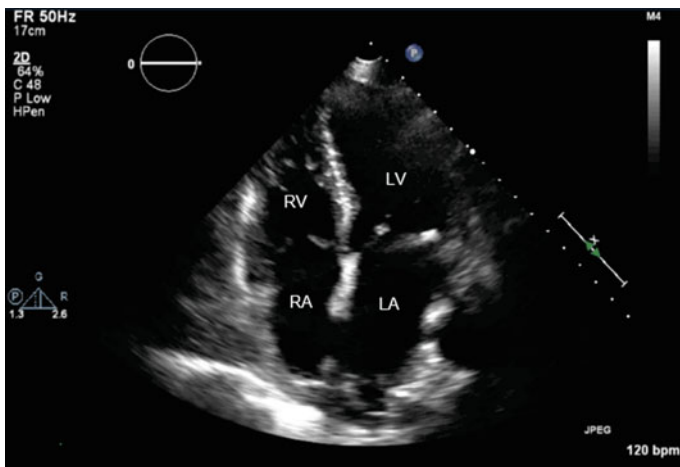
Apical four-chamber view. *RA* right atrium; *RV* right ventricle; *LA* left atrium; *LV* left ventricle
